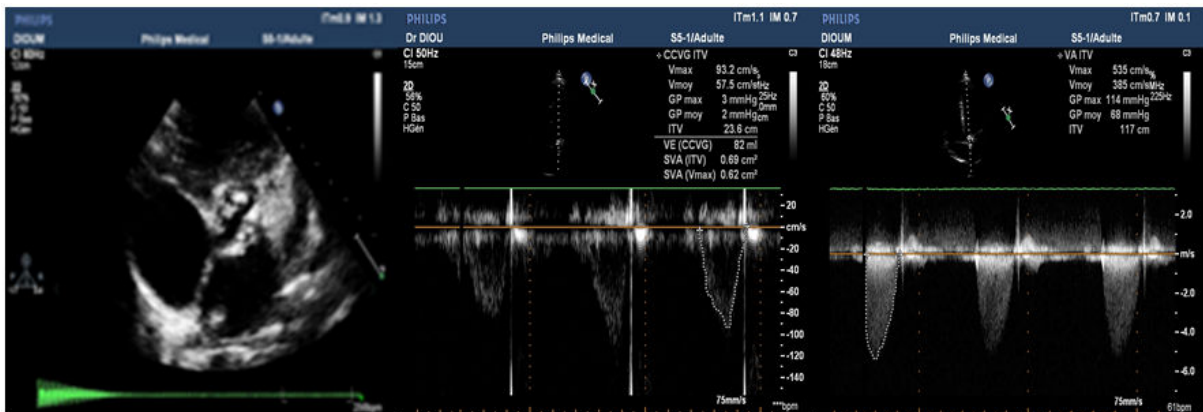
A: Transthoracic echocardiography parasternal short axis showing calcifications of aortic valve with reduced opening, B: Continuous-wave Doppler measurement of mean gradient, C: Pulsed-wave Doppler measurement of aortic valve area.
